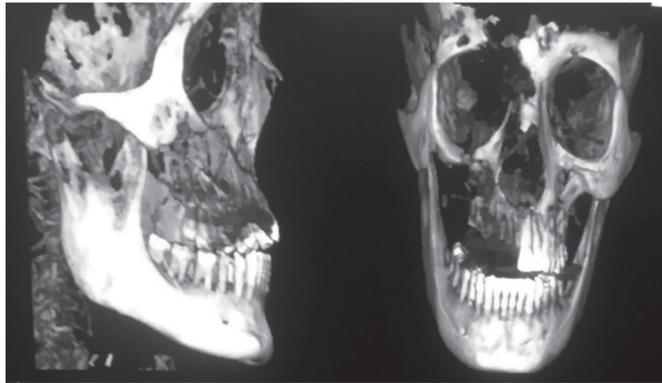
CBCT images showing the extent of destruction in the right maxilla
